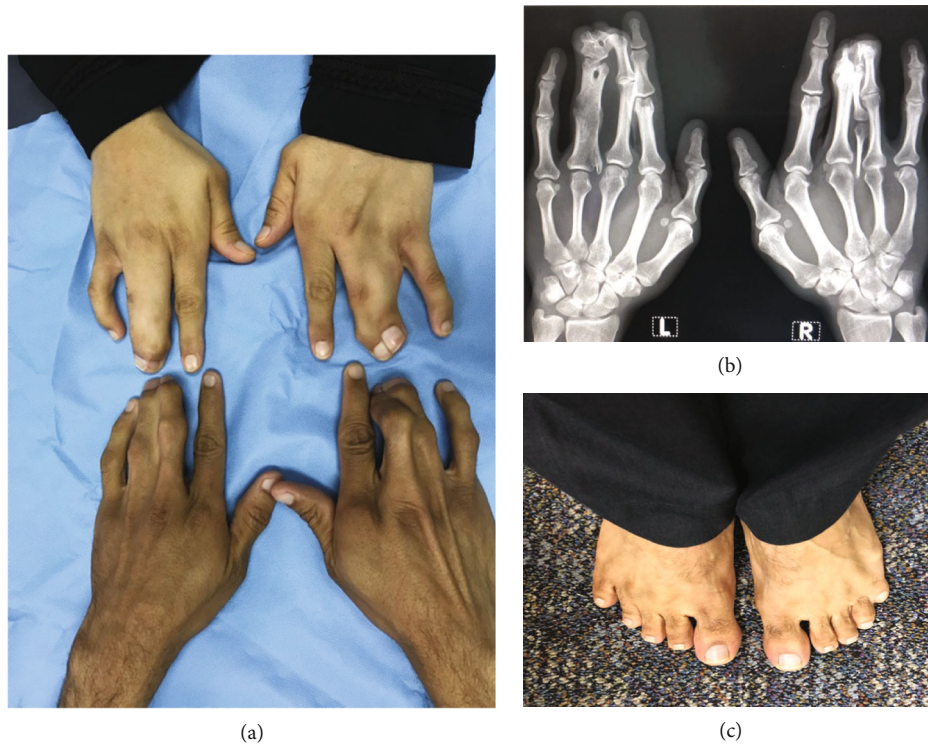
The phenotypes in the heterozygous parents: (a) the hands of the mother (above) and father (below) showing synpolydactyly of the third and fourth digits; (b) X-ray of the hands of the father showing the duplication within syndactyly; (c) the feet of the father showing bilateral little toe brachydactyly and webbing between the 4th and 5th toes in the left foot.
